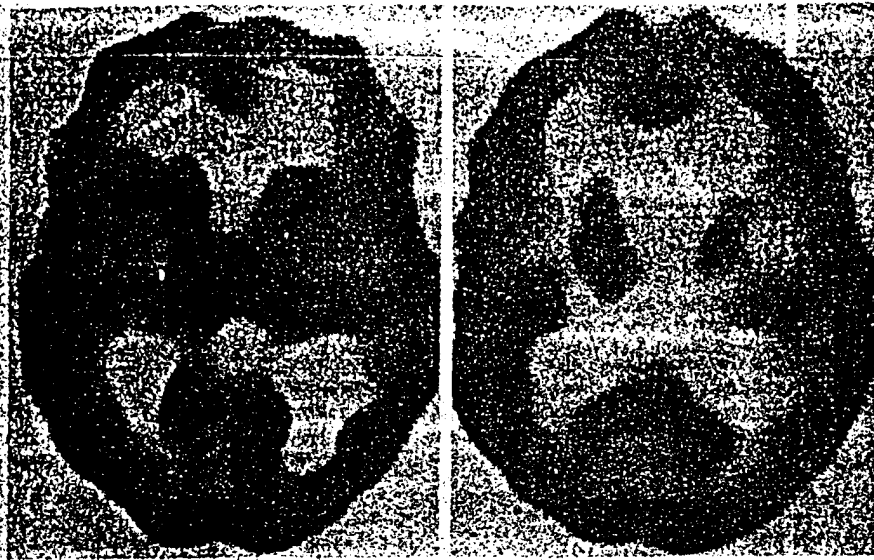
Axial single-photon emission computed tomography images demonstrating reduced technetium Tc-99m-hexamethylpropyleneamine oxime uptake in the left thalamus and left dorsolateral and anteromedial frontal lobes.
